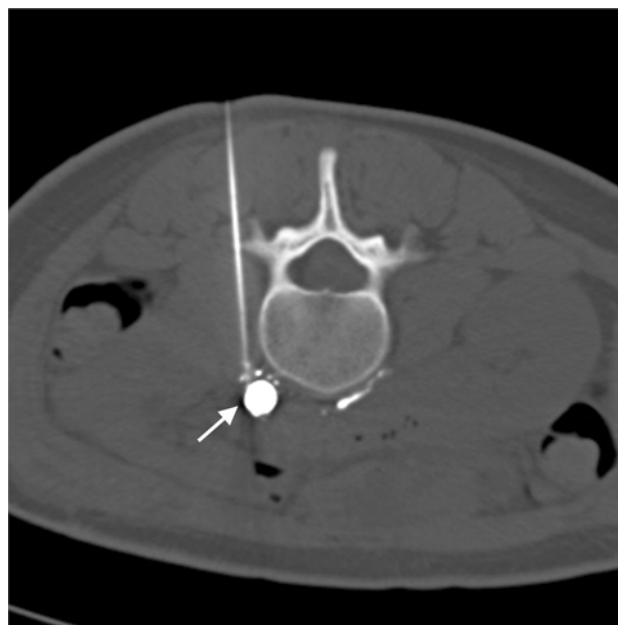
The pool of ethiodized oil opacified by the lymphangiography (*arrow*) was punctured under computed tomographic guidance with a 19-gauge needle via a transvertebral approach
